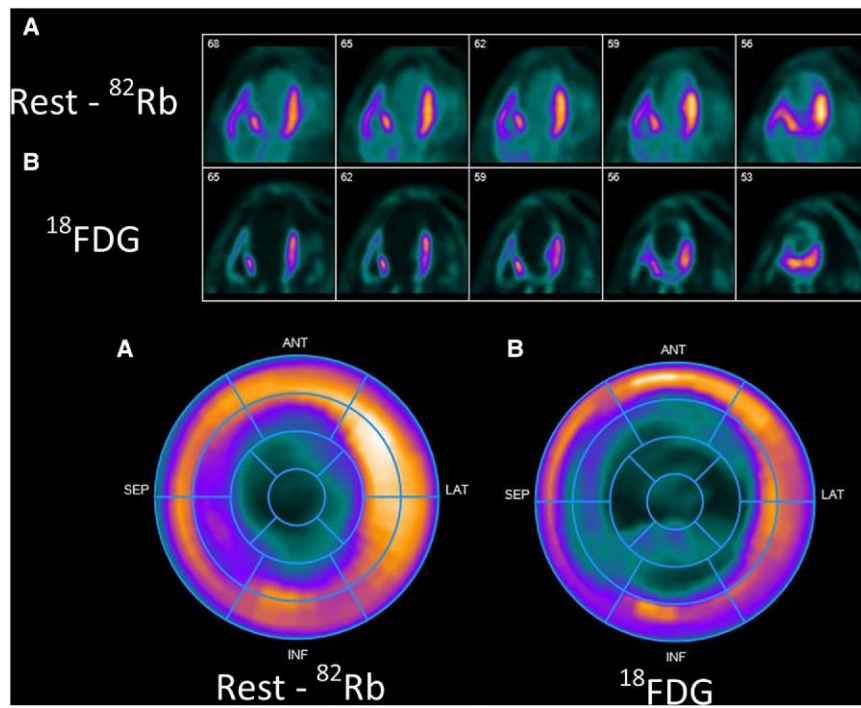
(A) Large fixed perfusion defect in a left anterior descending distribution on resting ^{82}Rb -chloride imaging. (B) Viability imaging shows no FDG uptake in these segments, demonstrating scar.
